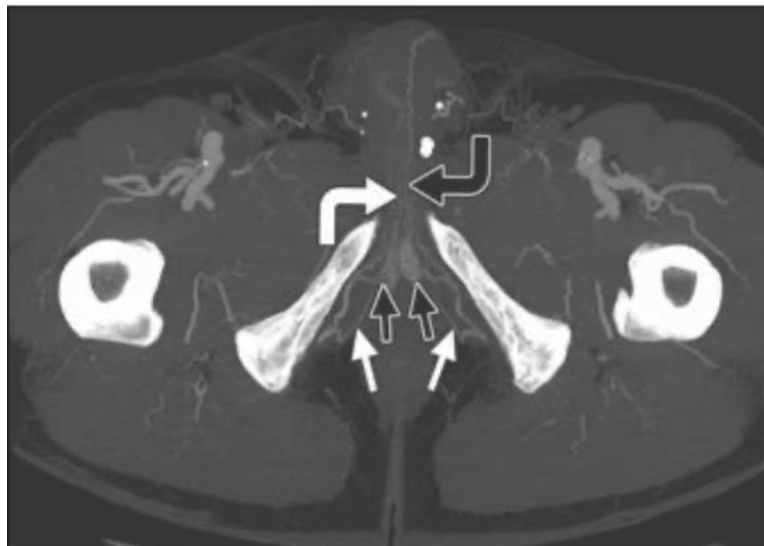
An axial MIP reformatted CT angiography of the penile artery.
